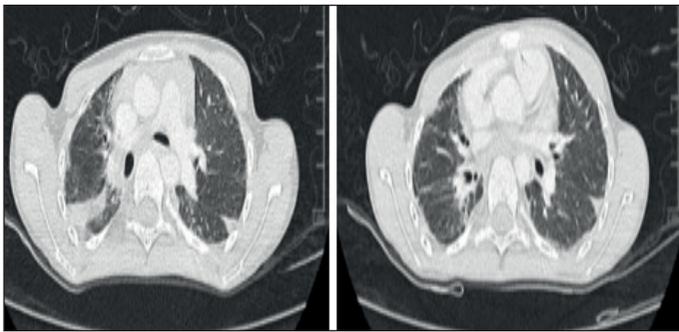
Chest CT performed before nintedanib treatment. Axial CT images show bronchiectasis, peribronchial thickening and reticulation consistent with pulmonary fibrosis.
